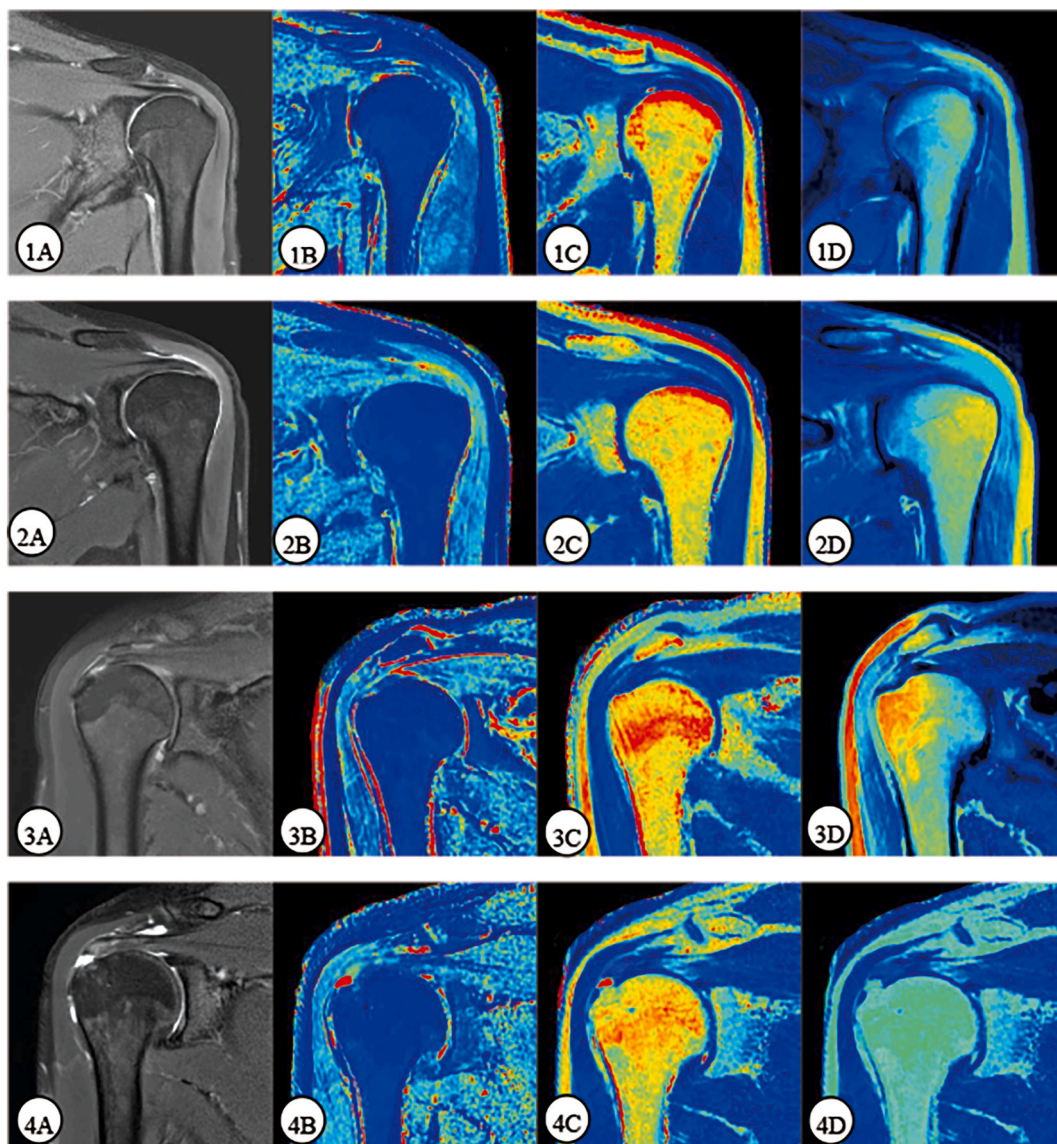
Magnetic resonance imaging (MRI) images of different grades of RCI. (A–D) Grayscale images (A), T1-weighted (T1W) mapping (B), T2-weighted (T2W) mapping (C), and PD mapping (D) images of grade I, II, III, and IV RCI.
